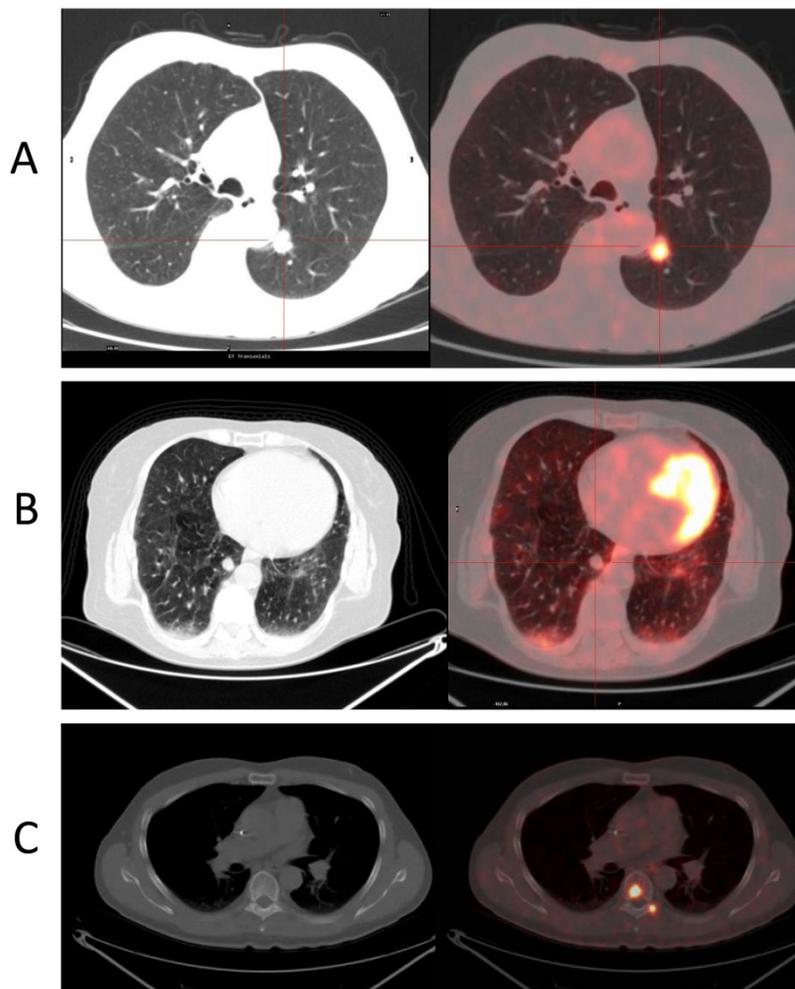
Lung cancer. Transaxial images of CT (left) and FDG-PET/CT (right) in three different patients. A: A male smoker with 2 cm lump in left lung (red cross hair). With CT alone the risk of this lump being cancer is 50%. The lump has a very high FDG uptake, which is typical for fast growing cancers and the combined image indicates an 80% risk of cancer. B: A non-smoking female with a 1.5 cm lesion that has no FDG uptake (the large yellow area is the heart muscle). The negative predictive value of the combined image is 99%. C: CT with a bone window setting is negative for bone metastases. PET shows two small metastases with very intense uptake. This pattern indicates infiltrative growth in the bone marrow with minimal destruction of bone structure and might precede positive findings on CT alone by several months.
